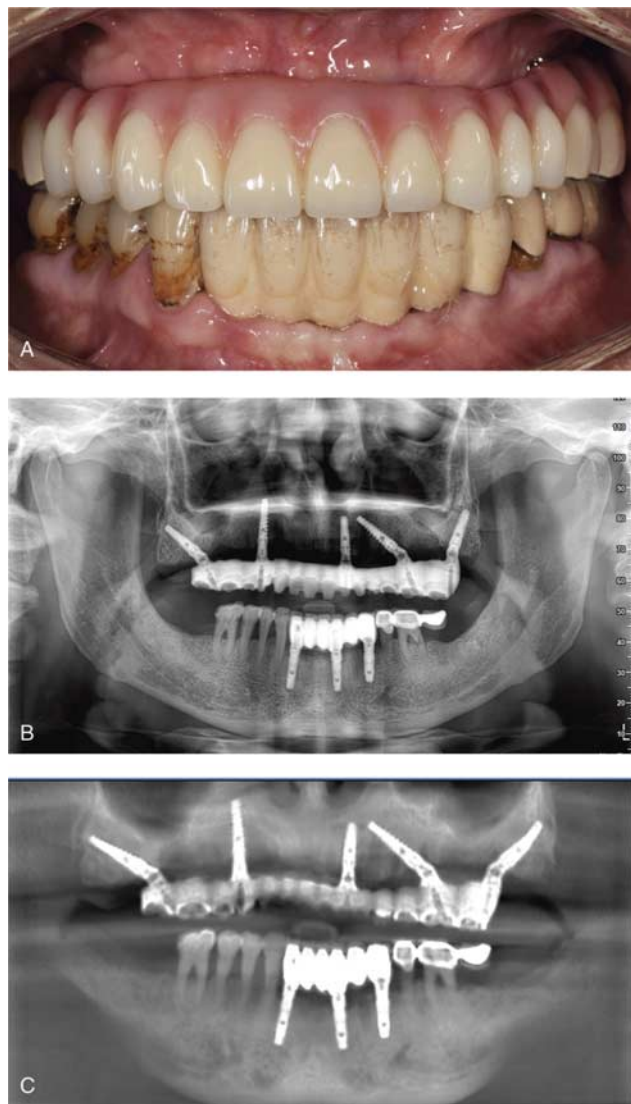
(A) At immediate restoration delivery, a panoramic x-ray showed good fit of the implant-prosthetic connections. (B) At final restoration delivery, a panoramic x-ray showed good fit of the implant-prosthetic connections and crestal bone stability. (C) Two years after placement of the final restoration and functional loading, CBCT demonstrated ideal crestal bone stability and no bone loss. CBCT, cone beam computed tomography.
